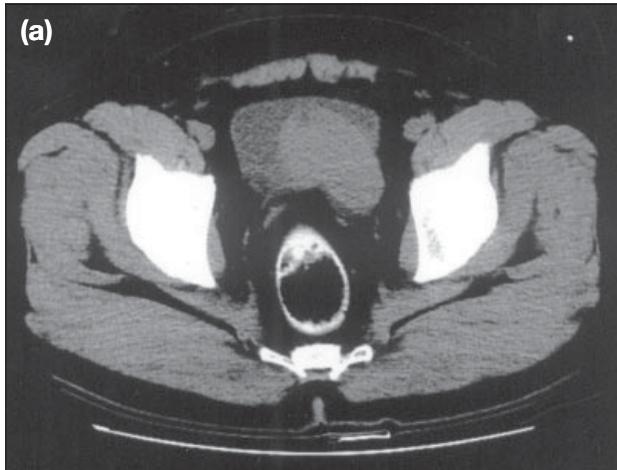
Axial computed tomography scan of the pelvis. (a) A large well-defined tumour mass is shown on the left side of the urinary bladder. (b) The tumour at the left side of the urinary bladder shows homogenous contrast enhancement.
